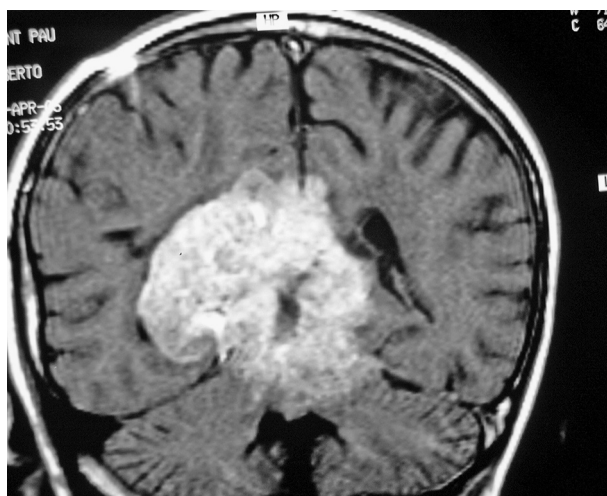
T<sub>1</sub>-weighted gadolinium-enhanced MRI of a recurrent pineoblastoma showing the ventricular shunt.
